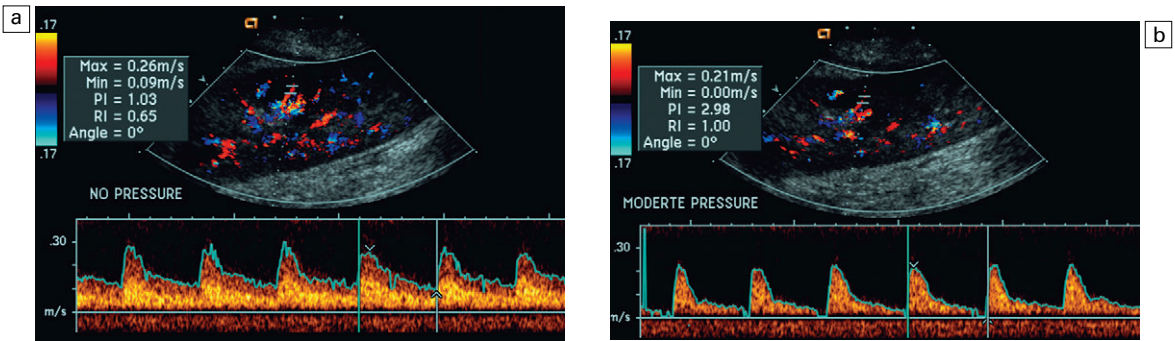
(a) Spectral Doppler tracing of an interlobar renal transplant artery. This tracing was obtained with the transducer gently contacting the lateral abdominal wall. The resistive measures approximately 65%. (b) The same vessel is now interrogated with moderate pressure applied with the transducer. Note the increase in diastolic velocity with result and elevation in resistive index to 100%. Pressure applied by the sonologist via the transducer can increase the resistance to arterial inflow in any organ or vessel.
